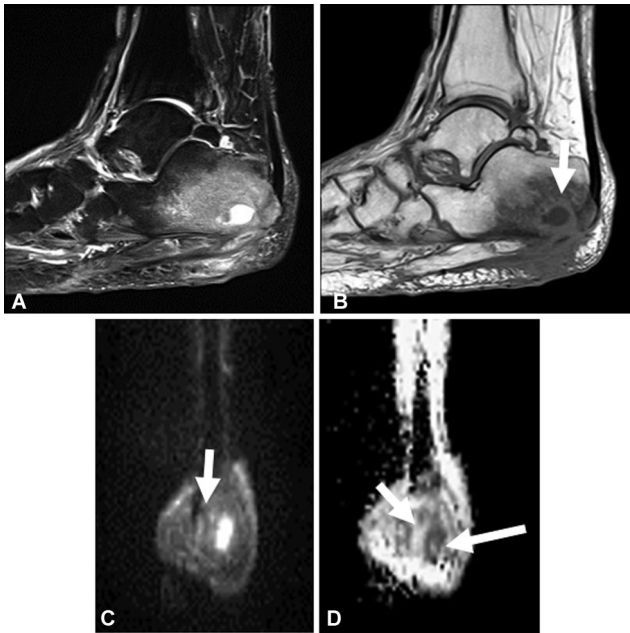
Patient with calcaneal osteomyelitis and intraosseous abscess. (A) Sagittal short tau inversion recovery (STIR) and (B) T1W images of the left ankle showing the “penumbra sign” (arrow). Corresponding (C) coronal diffusion-weighted imaging (DWI) and (D) apparent diffusion coefficient (ADC) map of the left ankle show the “ghost sign” (small arrow) and diffusion restriction in the region of intraosseous abscess (large arrow).
